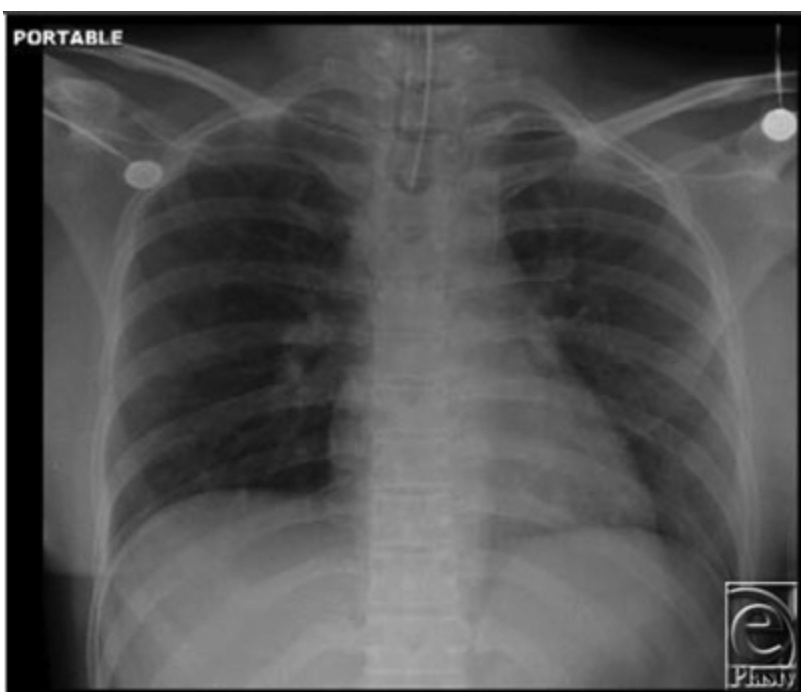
X-ray showing proper ETT placement.
